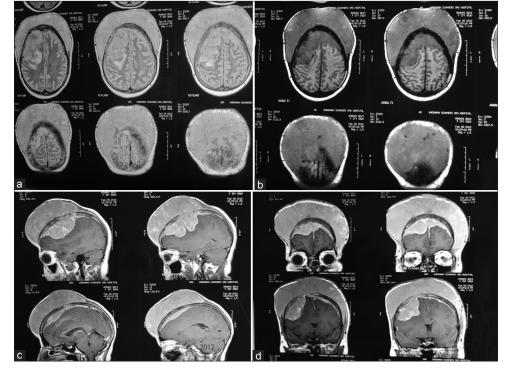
Magnetic resonance imaging brain showing isointense intra- and extracranial mass. (a) T2 FLAIR; (b) Axial T1, which enhances; (c) Sagittal post-GD; (d) Coronal post-GD
